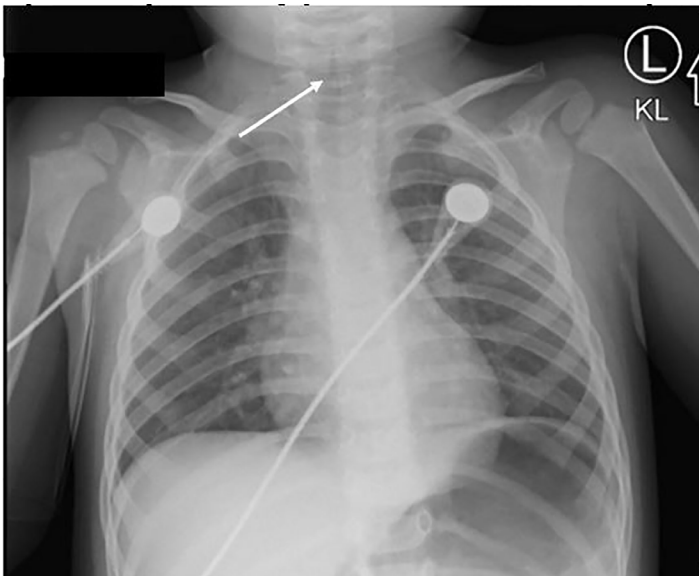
Chest radiograph of a 2-year-old male, showing subglottic tracheal narrowing (arrow) that resembles the steeple of a church – a positive “steeple sign” – which supports but is not required to diagnose croup.
